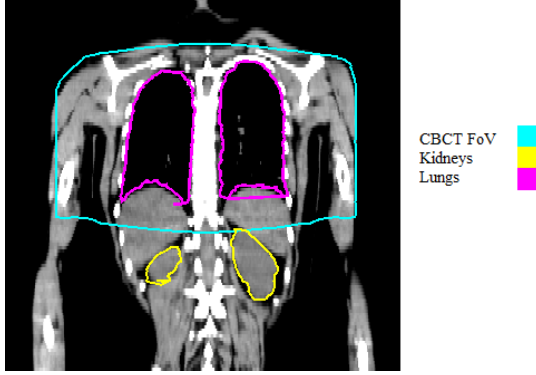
In this example, the field of view of the CBCT is shown in cyan. The kidneys are outside the field of view, and therefore have to be excluded for analysis.
